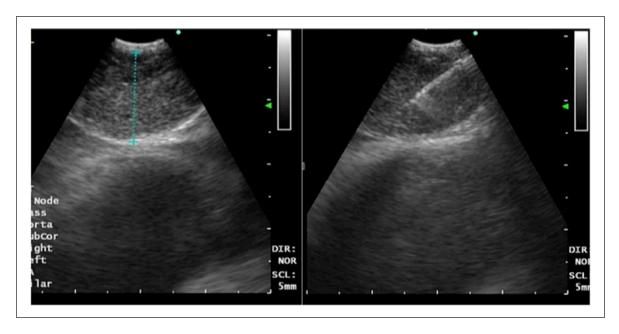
Endobronchial ultrasound view of the right paratracheal lymph node with transbronchial needle aspiration.
